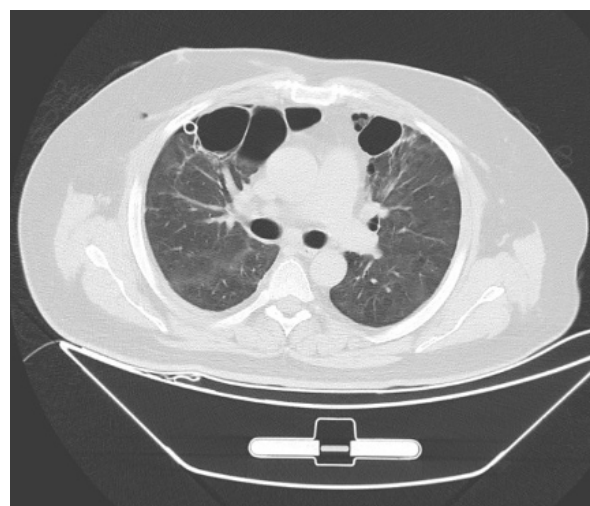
On thorax CT, bullae are observed in the middle lobe of the right lung and the lingular segment of the left lung.
